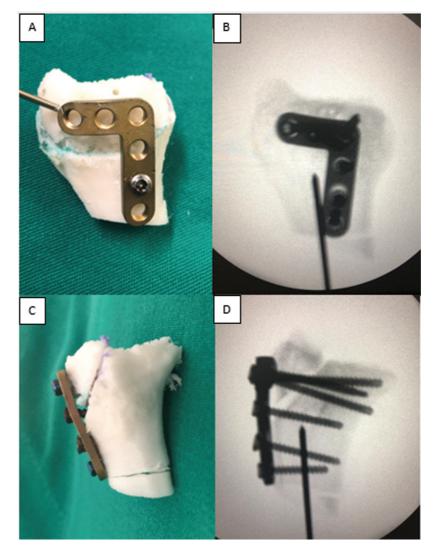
Dorsal view: planning of the corrective articular osteotomy of the distal portion of the right radius in a printed model (A), and fluoroscopic image after locked dorsal plate fixation at the distal radius (B). Lateral view: articular osteotomy of the distal radius and locked dorsal plate fixation in a printed model (C), and fluoroscopic image with corrected radiographic parameters (D).
